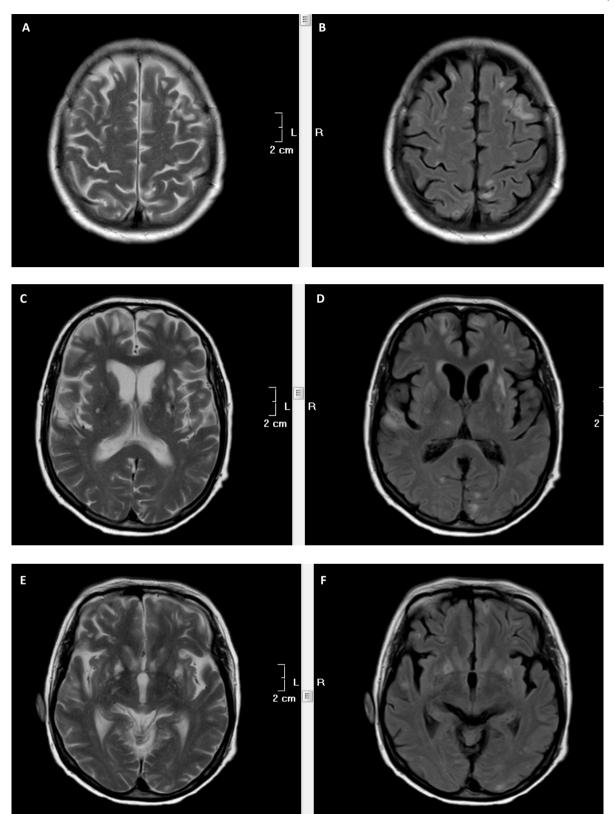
Native cerebral MRI axial T2 section (A, C, E), FLAIR (B, D, F) at the same comparison level. There are identified multiple small round lesions hyper dense in T2 (liquid), inhomogeneous FLAIR signal (determined by haemorrhages or calcifications), situated supra and infra-tentorial, cortical, sub-cortical and in the basal ganglia, predominantly on the left side.
